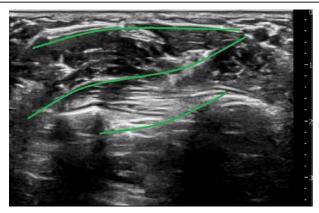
Neiguan point was guided by ultrasound. The fascial layer represented by the green line is the site of Neiguan point.
